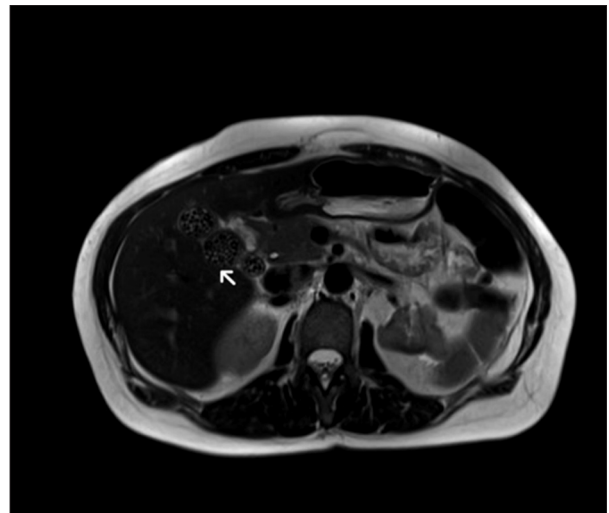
Preoperative examinations. In T1-weighted sequences, magnetic resonance cholangiopancreatography confirms the presence of cholecysto-choledochal gallstones.
